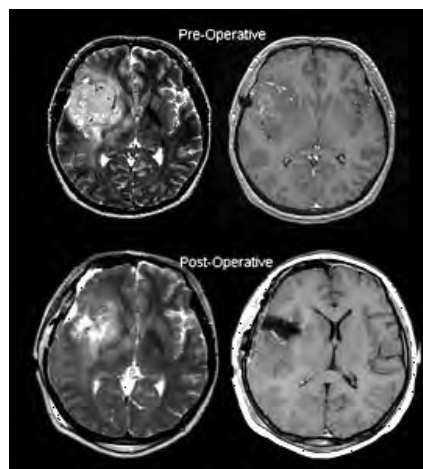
MRI images of a glioblastoma in the right frontal lobe before and after surgery.
